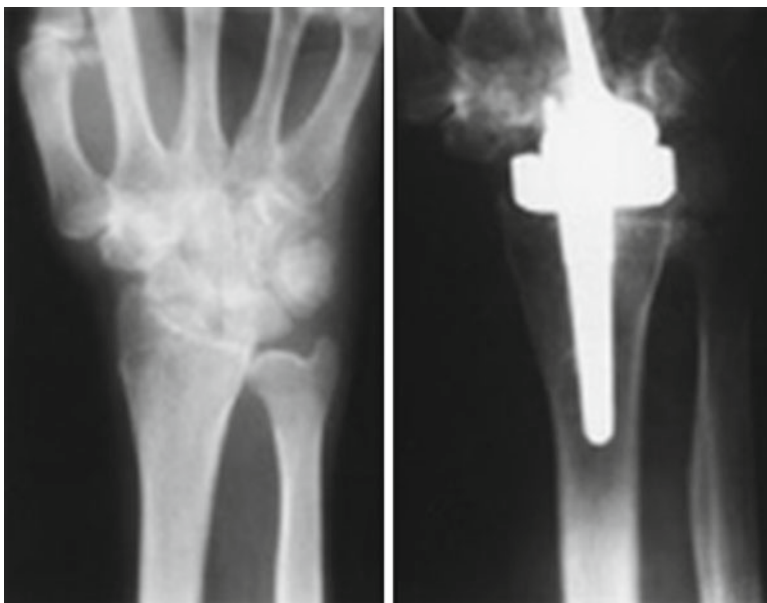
X-ray of a wrist with osteoarthritis before (*left*) and after (*right*) wrist replacement
